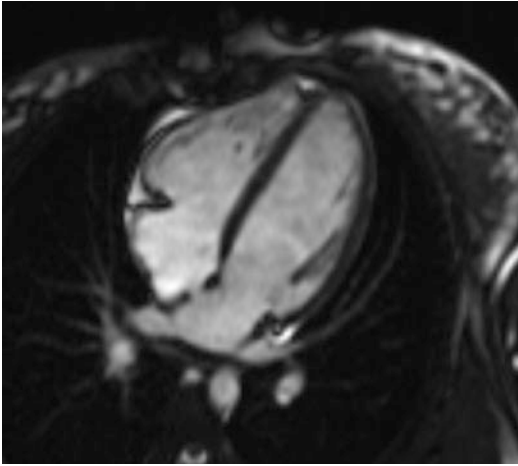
Isolated secundum ASD. Four-chamber view image obtained from cine TRUFISP MRI sequence demonstrates an ostium secundum defect of less than 10 mm in diameter. The QP/QS ratio was estimated to be 1.2:1
